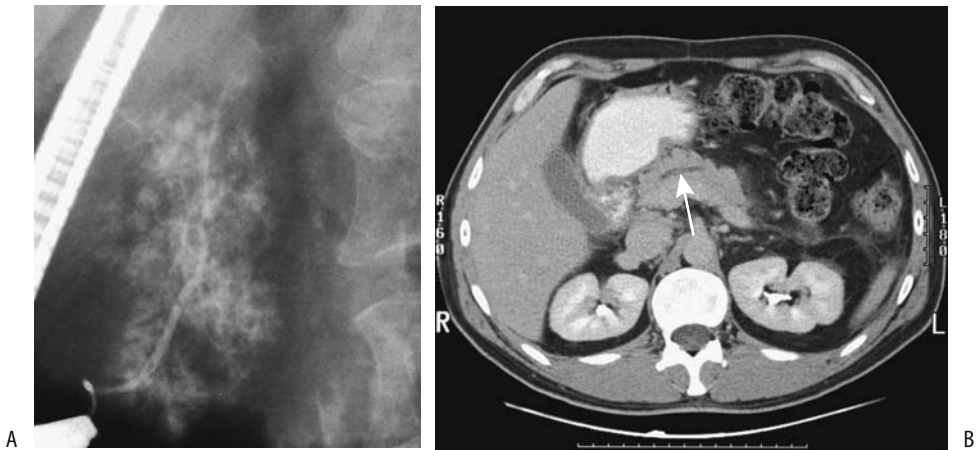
Pancreas divisum. A: Endoscopic retrograde cholangiopancreatography (ERCP) with contrast injection into the main papilla outlines only a short, narrow caliber duct of Wirsung. Parenchymal contrast is evident. B: Computed tomography (CT) identifies a dilated duct (arrow) not conforming to the usual course of the main pancreatic duct.
